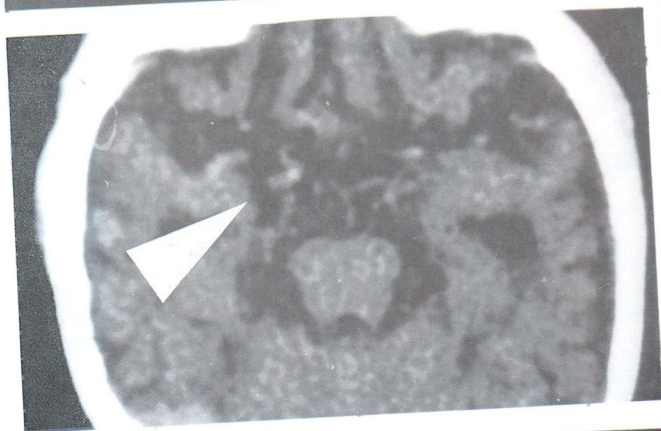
Enhanced axial CT scan of the brain showed cerebral and cerebellar atrophy with tortuosity of the arteries in the region of the circle of Willis
